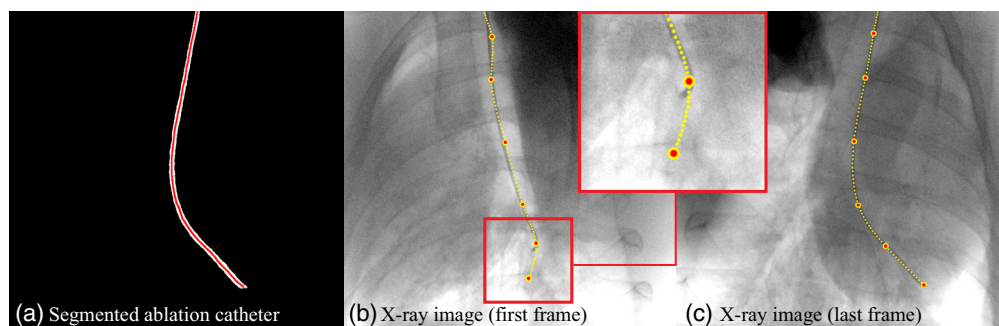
Single-plane device reconstruction method. (a) Binarized fluoroscopy image (last frame) with device centerline. Panels (b) and (c) are the first and last fluoroscopy frames of a sliding reconstruction window with reconstructed device control points corresponding to the last frame and path superimposed as yellow line and red dots. The device reconstruction was derived from all frames in the reconstruction window including the x-ray images shown in (b) and (c).
